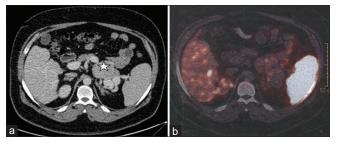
(a) Insulinoma lesion (*) identified on contrast-enhanced computed tomography (b) but not showing somatostatin receptor uptake
